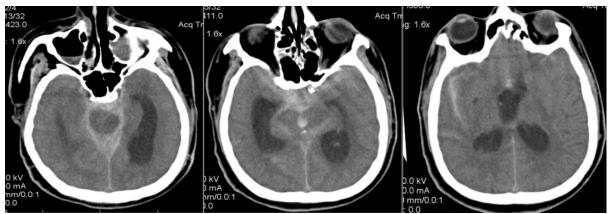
Head CT scan showing subarachnoid hemorrhage and acute hydrocephalus (from *Turliuc et al., 2013*)
